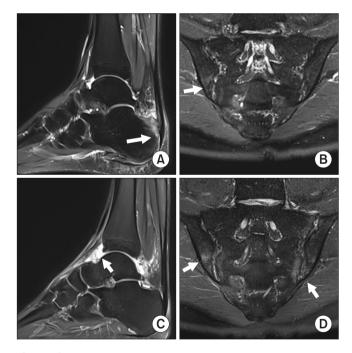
MRI of the ankle and sacroiliac joints in Twin A and Twin B. (A) Sagittal plain T2-weighted images of Twin A displaying tendinopathy of the left Achilles tendon (white arrow). (B) STIR images of Twin A displaying the sacroiliac bone marrow edema (white arrow). (C) Sagittal plain T2-weighted images of Twin B displaying synovial proliferation and joint effusion (white arrow). (D) STIR images of Twin B displaying bilateral sacroiliac bone marrow edema (white arrows). MRI: magnetic resonance imaging, STIR: short tau inversion recovery.
